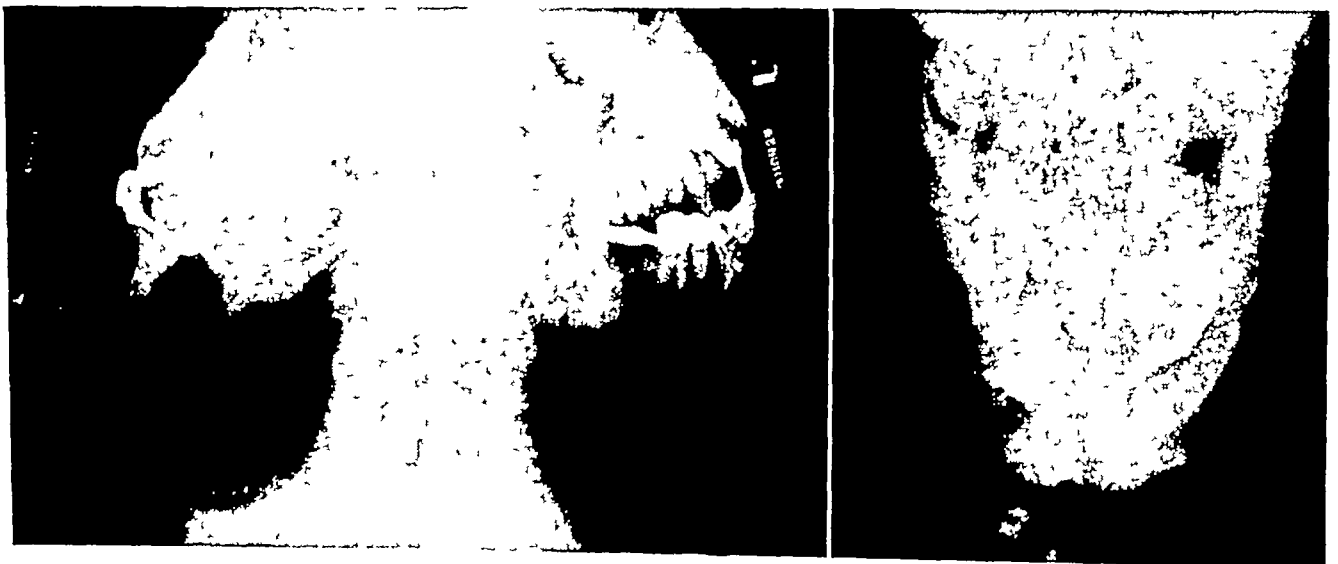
Early post-operative X-rays 4½ months p o (Left) Right oblique—Showing 32 mm gap filled by both a block of cortical cancellous bone mortised into position, packed and contoured with cancellous chips and held with figure of eight 38 gauge s.s. interosseous wire (Center) Left oblique—The mandibular nerve was left intact. Cancellous bone was loosely packed above, below and external to the mandibular nerve. A thin sheet of cortical bone was superimposed on the surface (Right) A.P. shows relation of bi-lateral grafts
